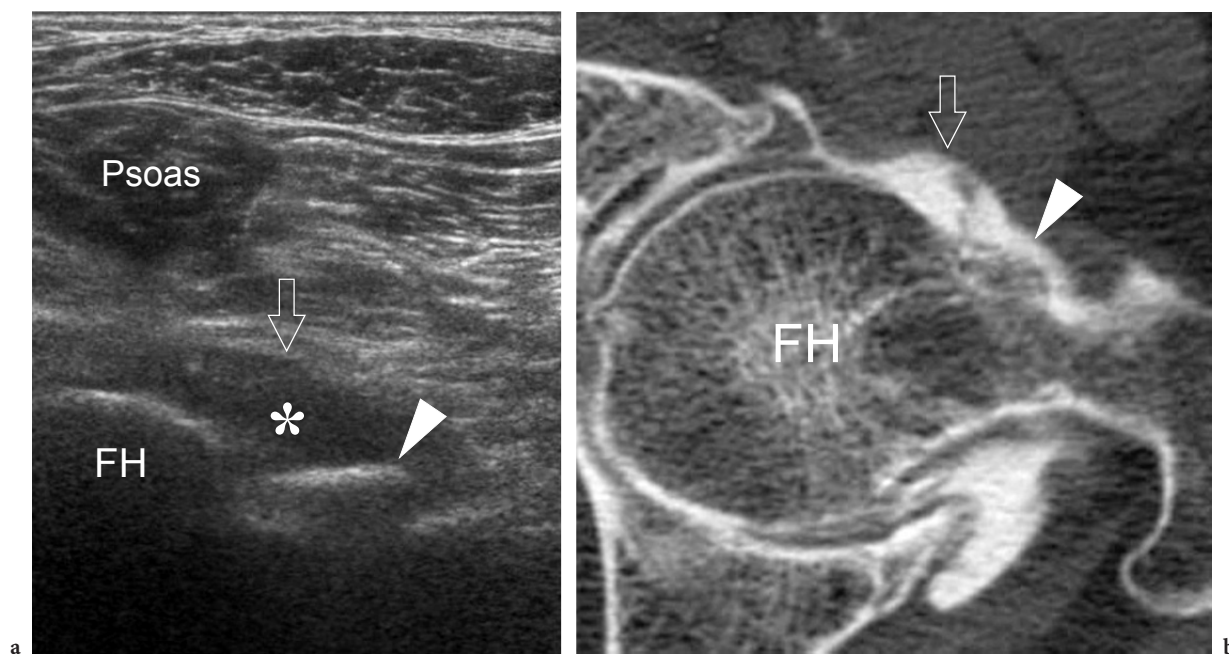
Marginal femoral osteophytes. a Transverse oblique 12–5 MHz US image over the anterior hip reveals a fluid effusion (*asterisk*) in the anterior recess of the hip joint causing bulging of the anterior capsule (*arrow*). An anterior osteophyte (*arrowhead*) appears as a well-defined hyperechoic prominence with posterior acoustic shadowing located at the junction of the femoral head (*FH*) and neck. b Corresponding transverse oblique CT-arthrographic image confirms the presence of the femoral osteophyte (*arrowhead*)
